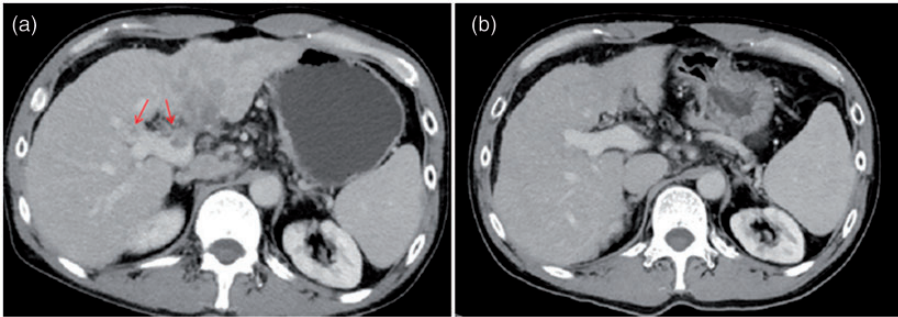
Computed tomography imaging of the 49-year-old male patient diagnosed with hepatocellular carcinoma. (a) The tumor invading the portal vein before treatment (indicated by the arrows). (b) The tumor thrombus disappeared after treatment.
